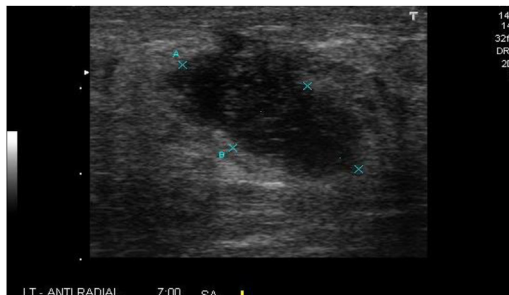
Sonographic appearance of subareolar abscess. Note the fairly well-circumscribed, heterogenous, hypoechoic mass.
